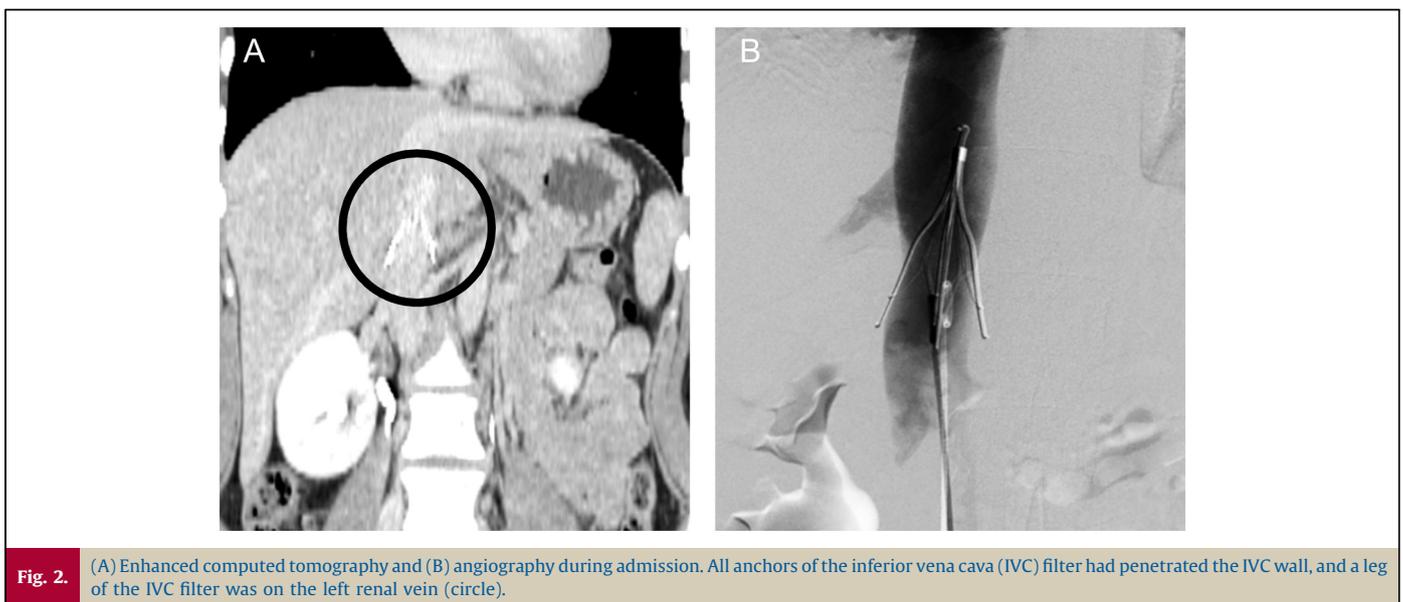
(A) Enhanced computed tomography and (B) angiography during admission. All anchors of the inferior vena cava (IVC) filter had penetrated the IVC wall, and a leg of the IVC filter was on the left renal vein (circle).
